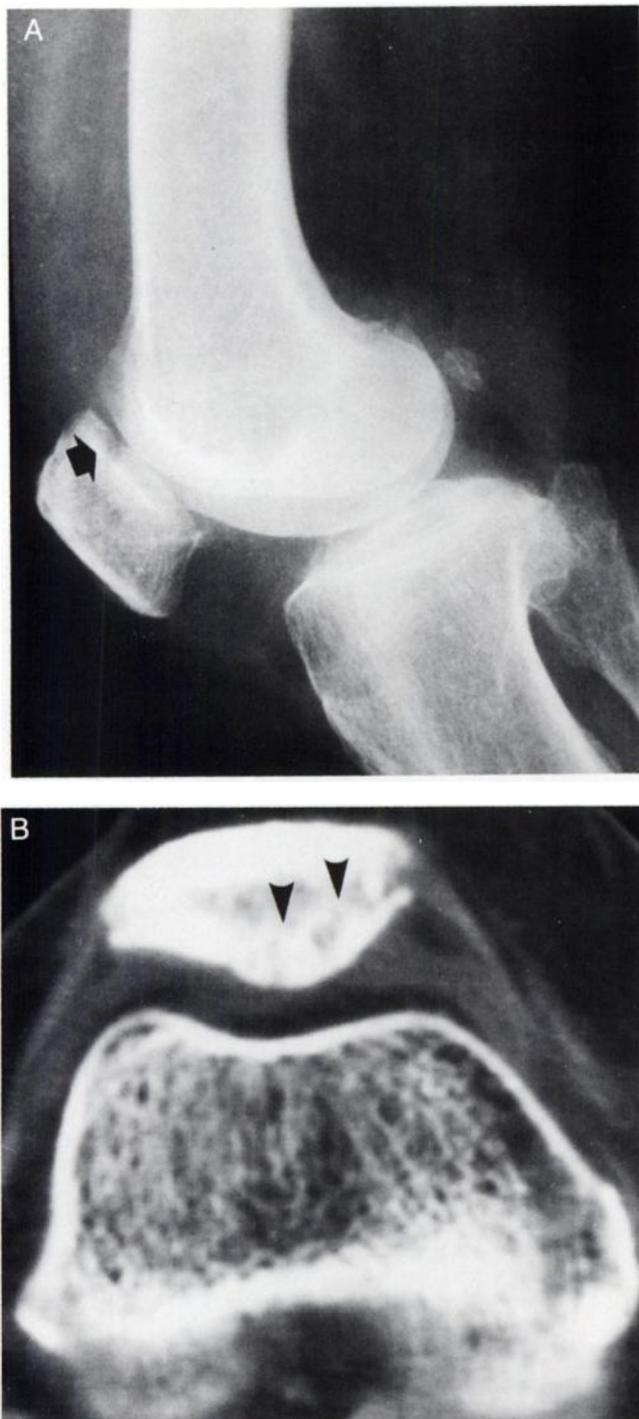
(A) Lateral x-ray of the right knee in Patient 6 (Fig. 1F) with chondromalacia patellae and concurrent osteoarthritis shows classic spotty osteolysis in the upper central, retropatellar facet (arrow) and periarticular bone irregularity and osteophytosis. (B) An axial CT scan through the patella demonstrates cysts and bone aberrations in medial facet (arrowheads). Note marked thinning and slight irregularity of the femoral condylar cortex.
